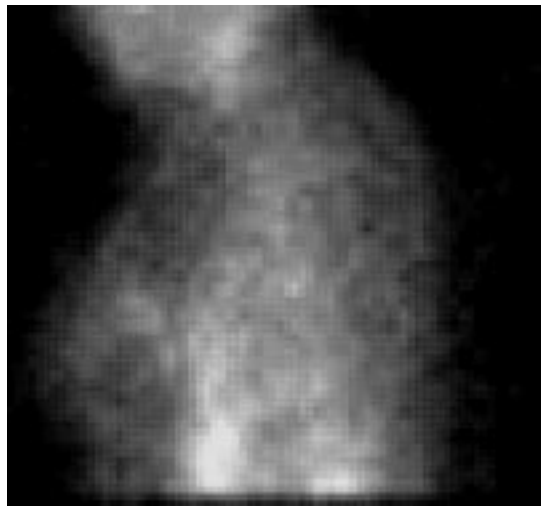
Image of the uptake of  $^{99m}\text{Tc}$ -MAb-170H.82 in primary breast cancer. SPECT slices show breast tumor uptake of Tc-99m MAb-170H.82 in the left breast (SPECT slices 16 to 22 - increase intensity as needed). This uptake corresponds to a known lesion.
